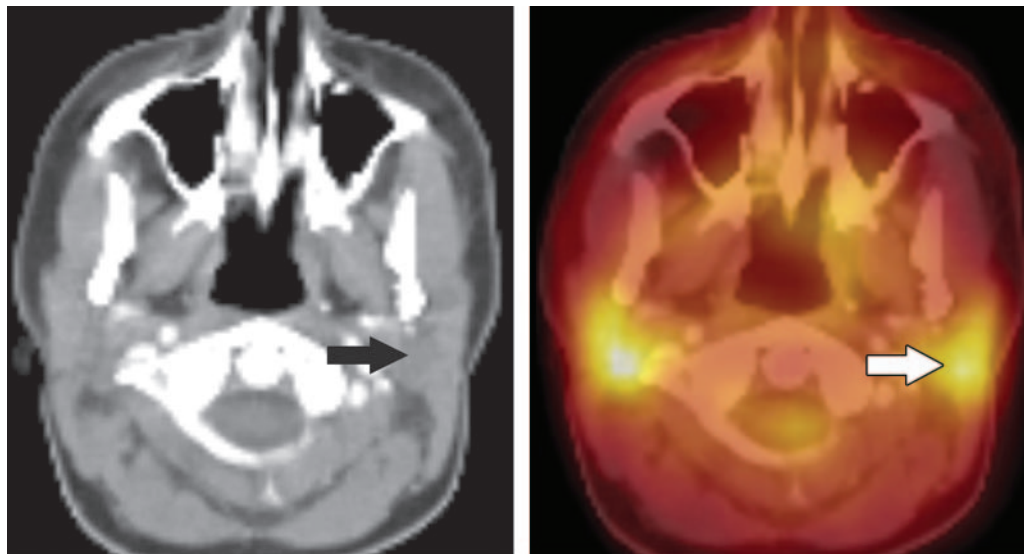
Physiologic parotid uptake. Axial CT (a) and fused PET-CT (b) scans show moderate symmetric FDG uptake in the parotid glands (arrow).
